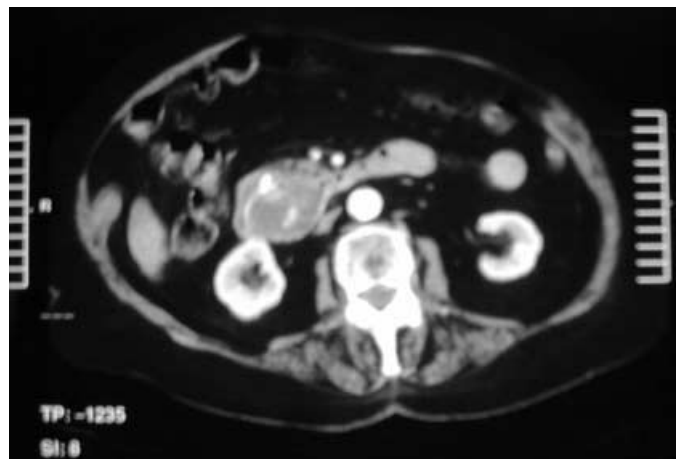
CT scan of abdomen showing large calculus occluding duodenum.
